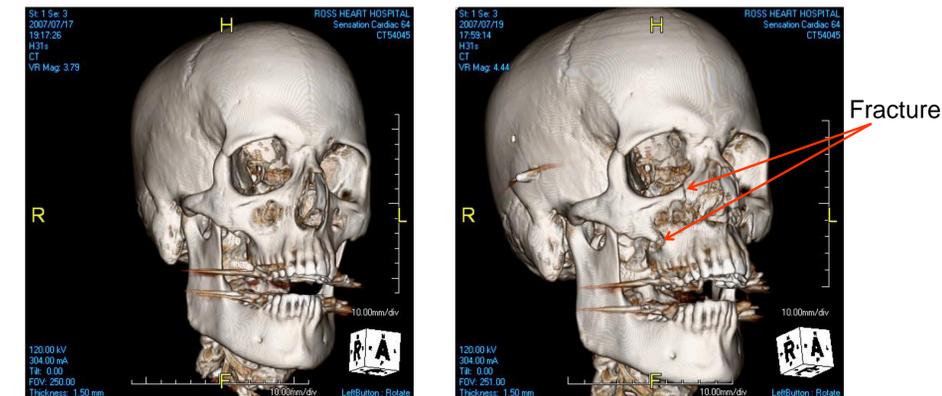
Pre-test (left) and post-test (right) CT scans for Chin02
